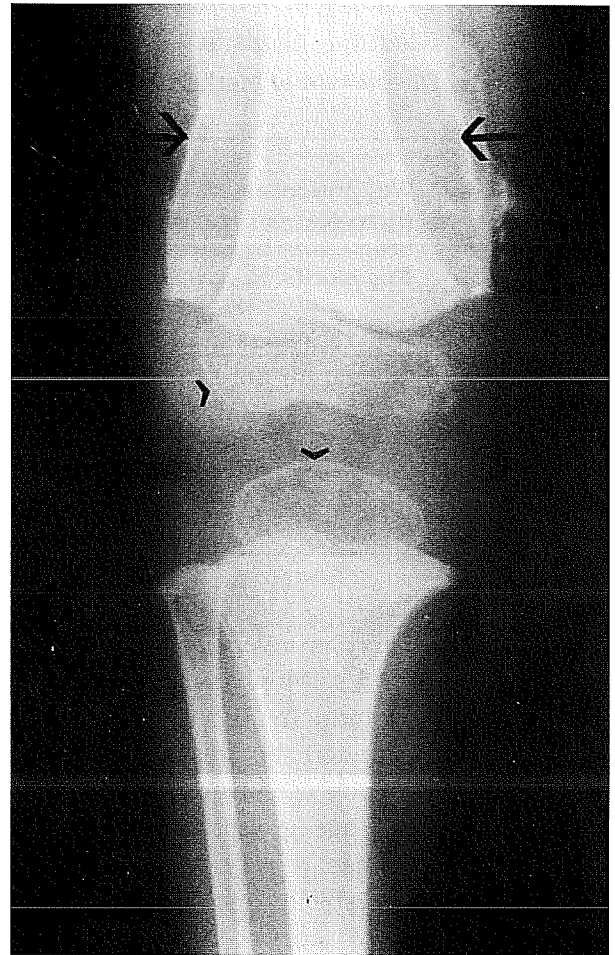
X-ray of the right femur with knee joint shows subperiosteal hemorrhage (arrows) and Wimberger's ring (arrowheads) characterized by osteoporosis at the end of the shaft and at the epiphyseal ossification center in contrast to the dense periphery.
